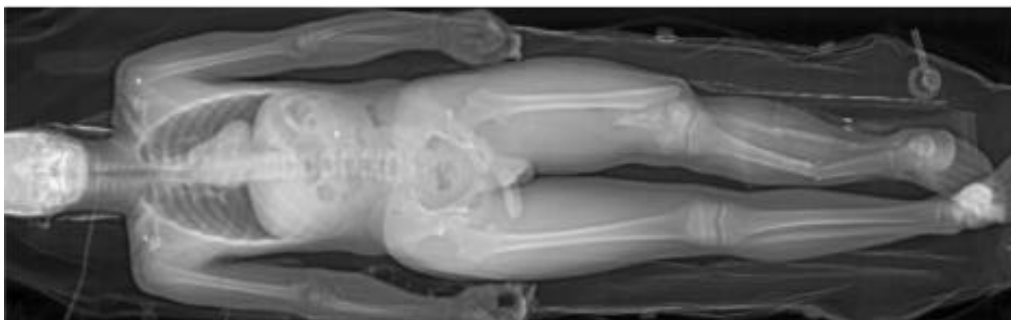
LODOX whole body lateral and b) antero-posterior radiography [60]
